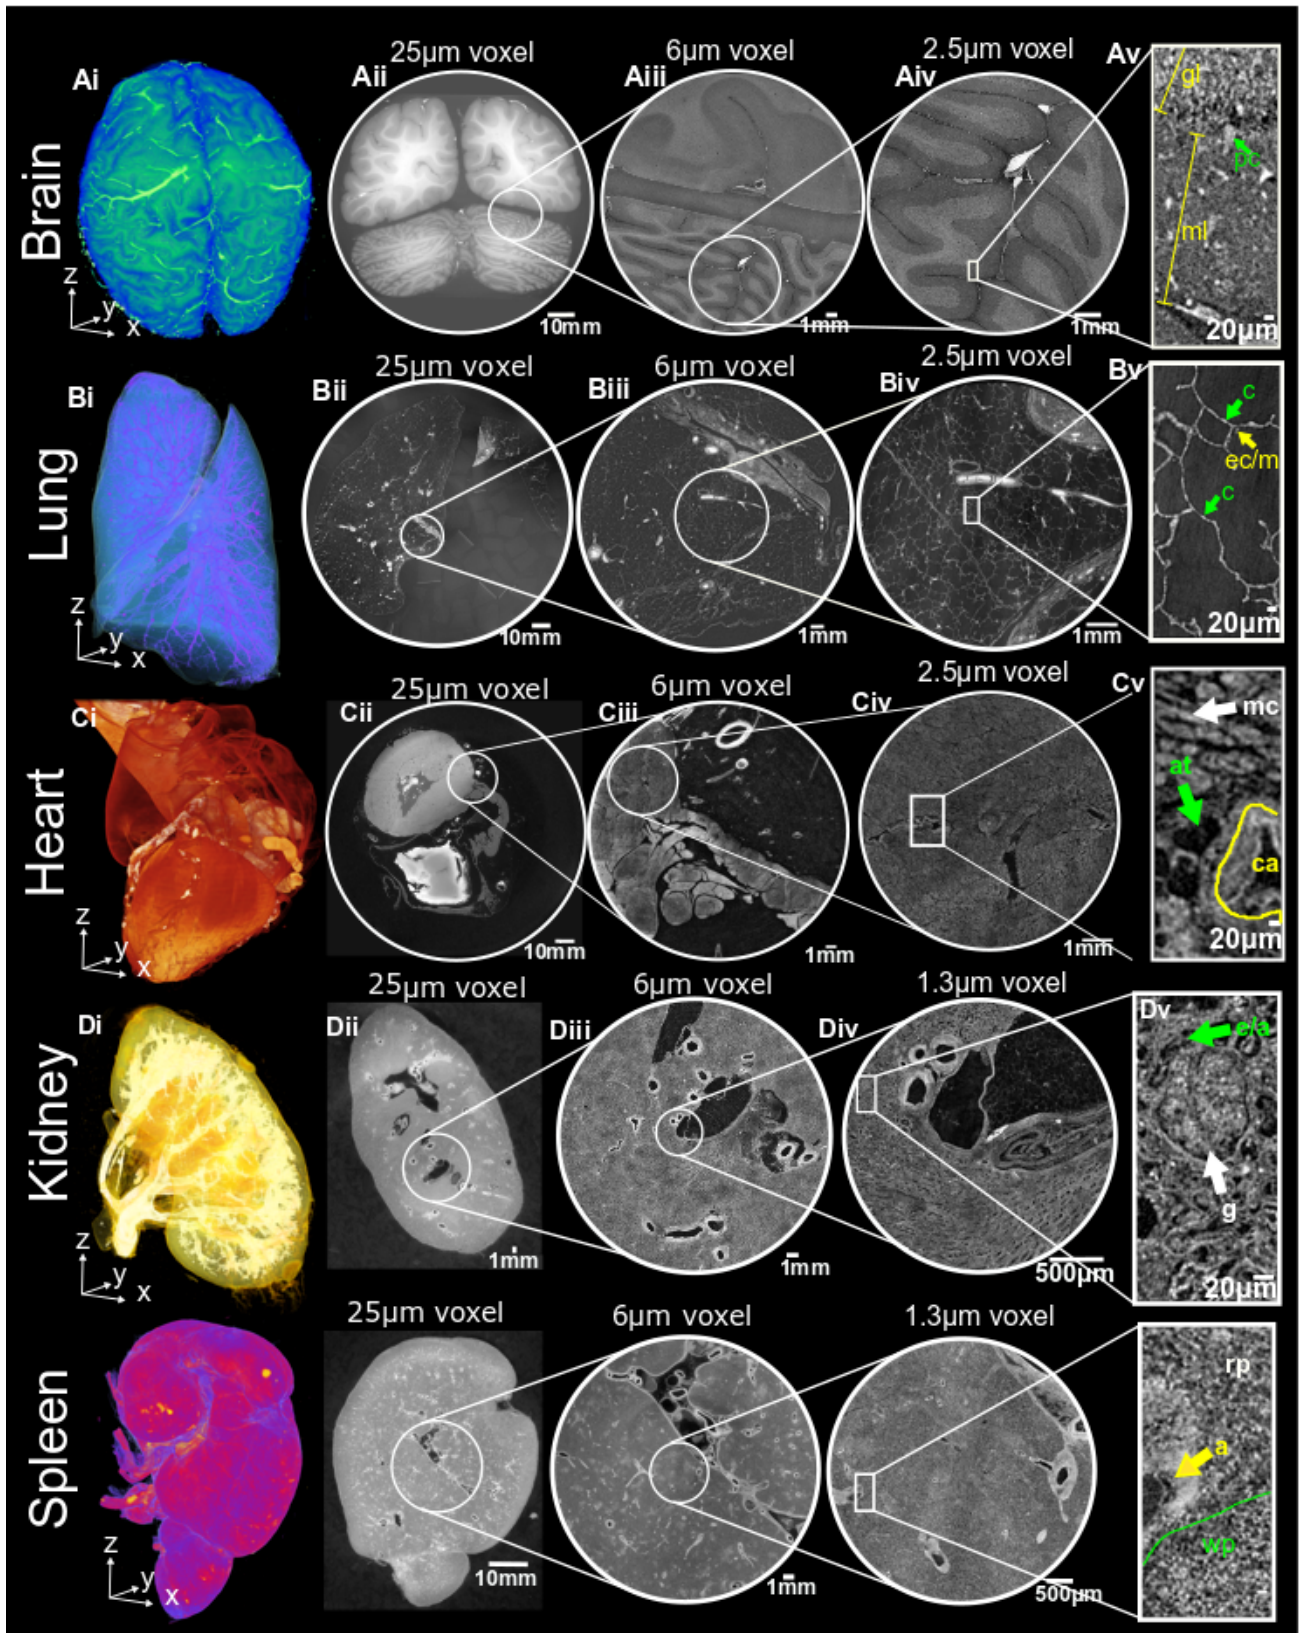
HiP-CT has redefined the resolution at which organs can be imaged, and an “atlas of organs” will be available from the ESRF website of the organotypic structural and functional units of whole human organs. For each organ A) brain, B) lung, C) heart, D) kidney, E) spleen, panel (i) shows a 3D rendering of the whole organ from scans at 25µm. Subsequent 2D slices (ii-iv) show the higher resolution scan area marked on its preceding scan. (v) shows a digital zoom of the highest resolution image and in each case the arrows depict a characteristic structural feature of the respective organ. Av) molecular layer (ml), granular layer (gl), purkinje cell (pc). Bv) capillary (c), epithelial cell/macrophage (ec/m); Cv) myocardium (mc), coronary artery (ca), adipose tissue (at). Dv) efferent/afferent arteriole (e/a), glomerulus (g). Ev) red pulp (rp), white pulp (wp), arteriole (a).
